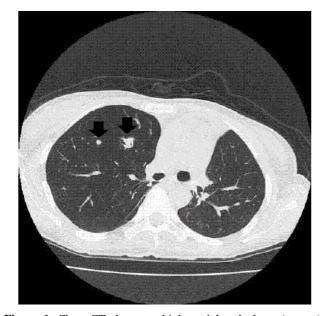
Chest CT shows multiple nodular shadows (arrows). CT-guided lung biopsy found that these shadows were sites of *Aspergillus fumigatus* infection.
